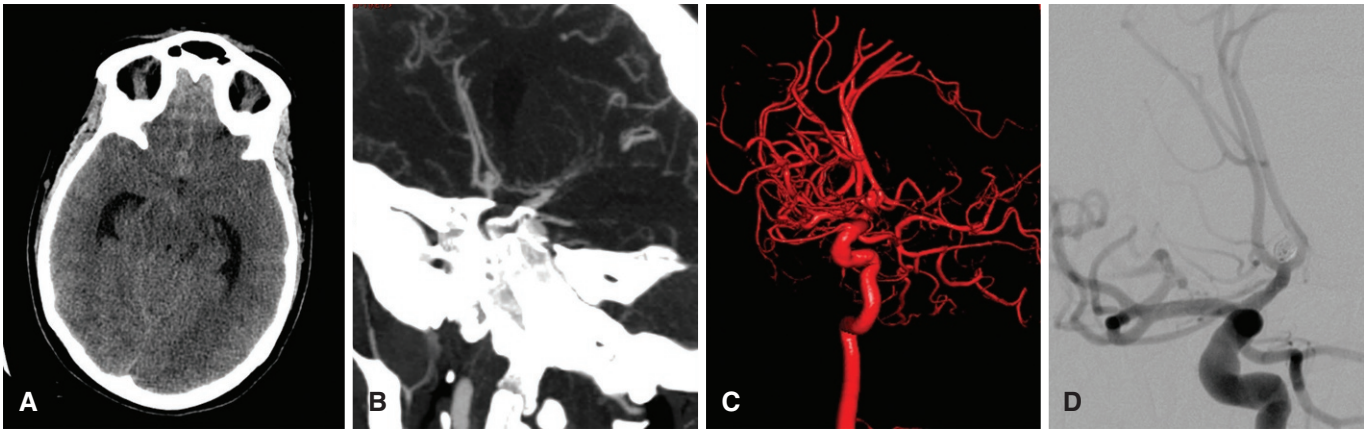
A 26-year-old female who presented with sudden-onset severe headache. A, Noncontrast computed tomography (CT) of head shows diffuse subarachnoid hemorrhage, mainly in the anterior interhemispheric fissure with moderate hydrocephalus. B, Maximum intensity projection images reconstructed CT angiogram shows a lobulated anterior communicating artery aneurysm at right A1/A2 junction. C, Conventional catheter three-dimensional angiogram shows ruptured anterior communicating artery aneurysm, which was coiled successfully by two coils (D) in the same sitting.
